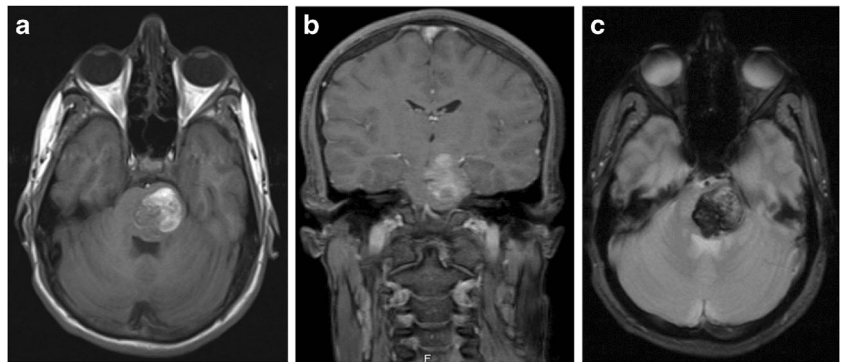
a–c T1 weighted MRI showing the presence of a bleeding lesion in the pons in the axial and coronal planes. Gradient echo showing the characteristic appearance of the bleeding cavernoma
